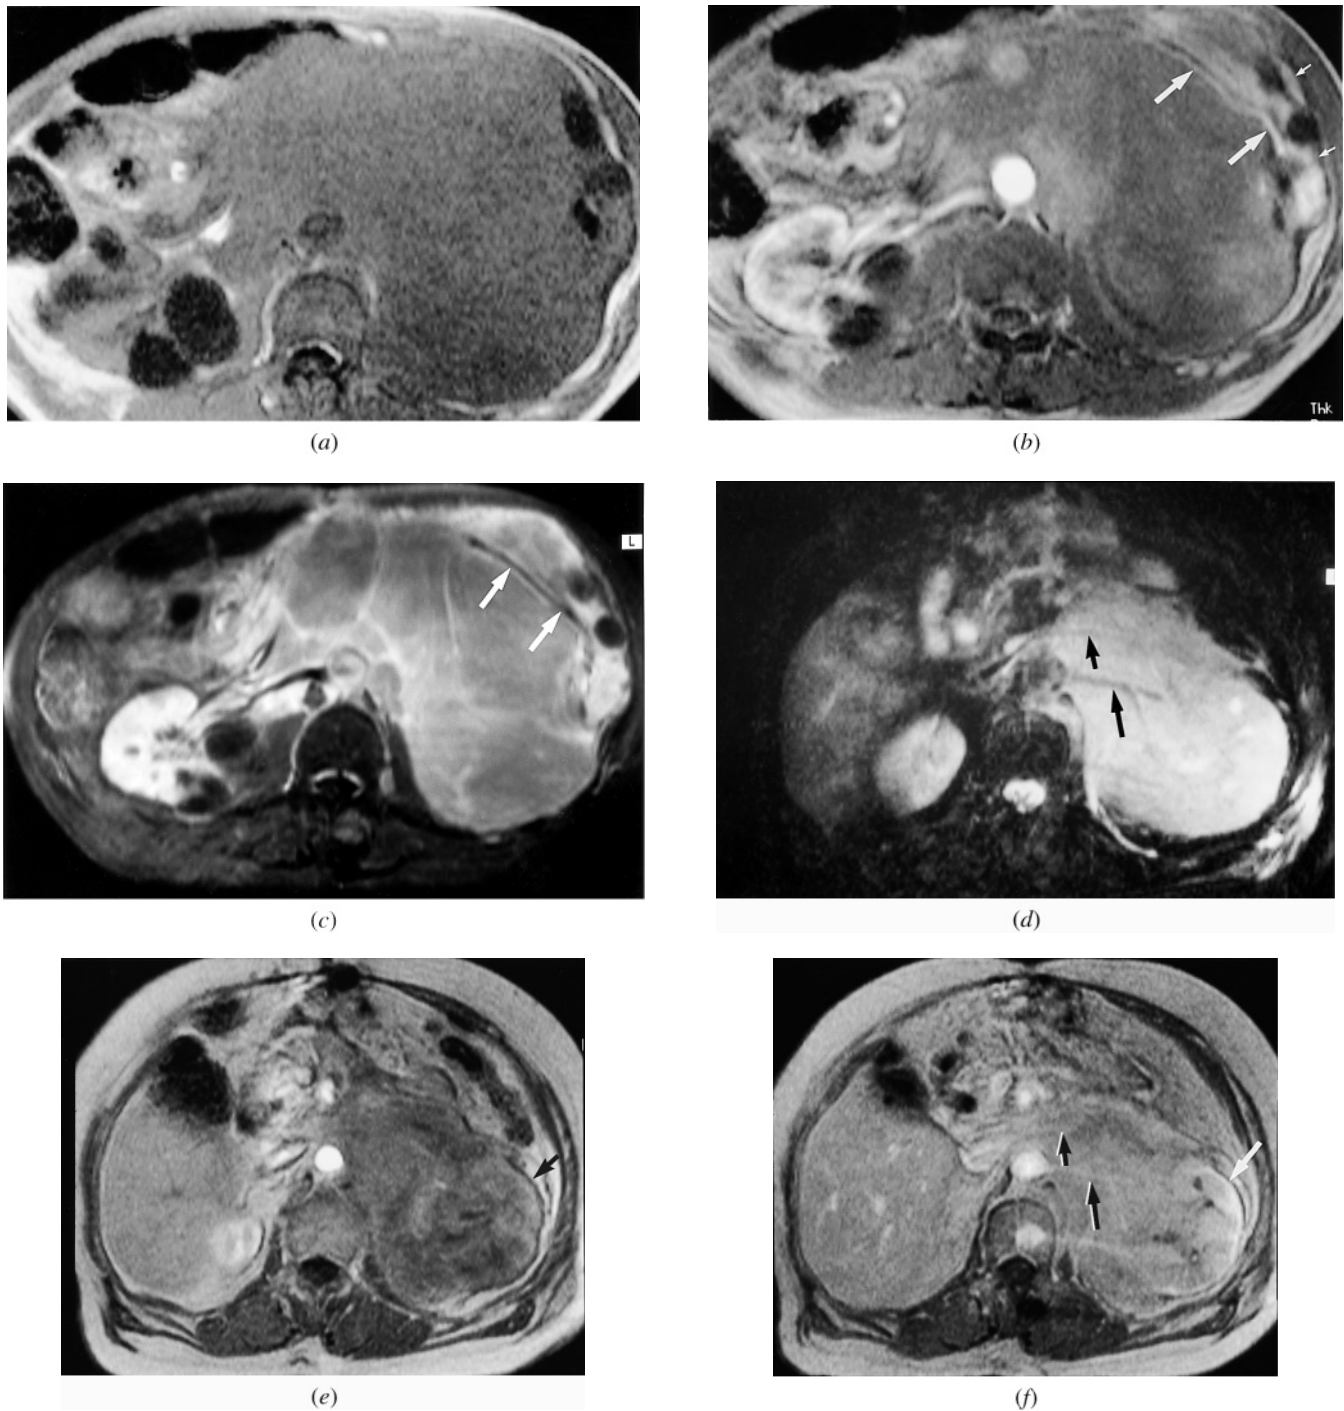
Renal lymphoma, large retroperitoneal mass invading kidney. T1-weighted precontrast SGE (*a*), immediate postgadolinium SGE (*b*), and late-phase fat-suppressed gadolinium-enhanced SE (*c*) images. A large retroperitoneal mass is present that is homogeneous and soft tissue signal intensity on the SGE image (*a*) and enhances minimally on capillary-phase (*b*) and interstitial-phase (*c*) images. On postcontrast, images lymphoma is moderately heterogeneous, with no evidence of necrosis. A thin rim of spared renal cortex is evident (small arrows, *b*), and the kidney is displaced anterolaterally. Tumor invades through the renal pelvis into the renal medulla. The renal artery is patent (arrows, *b*, *c*) but encased by lymphoma. Patency is shown by the presence of high-signal-intensity gadolinium in the artery on the immediate postgadolinium SGE image (*b*) and by flow void on the spin-echo image (*c*). In a second patient, a similar appearance of lymphoma is shown on T2-weighted fat-suppressed SE (*d*), T1-weighted immediate (*e*) and 90-s (*f*) postgadolinium SGE, and late-phase fat-suppressed postgadolinium SE (*g*) images. Lymphoma is mildly hyperintense on the T2-weighted image (*d*) and heterogeneous and mildly enhanced on capillary-phase (*e*) and interstitial-phase (*f*, *g*) gadolinium-enhanced images. The renal artery (arrows, *d*, *f*, *g*) and renal vein (small arrows, *d*, *f*, *g*) are encased by tumor but patent. Patency is demonstrated by the presence of high signal intensity on the SGE image (*f*) and signal void on the SE images (*d*, *g*).
